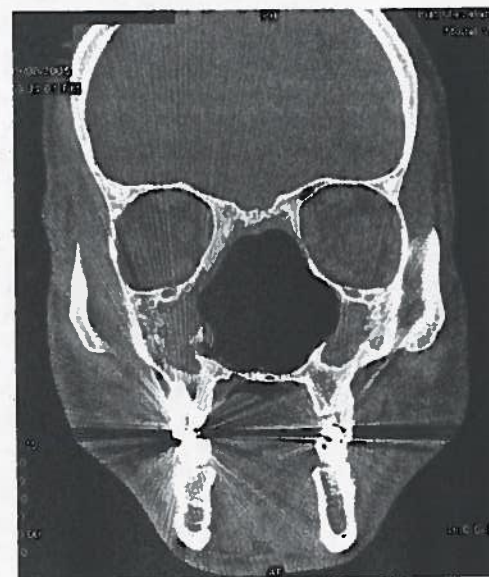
Coronal computed tomography scan from a 37-year-old man with long-standing Wegener's granulomatosis and four prior sinus surgeries. Note the "common cavity" configuration with complete erosion of nasal turbinates and septum.
